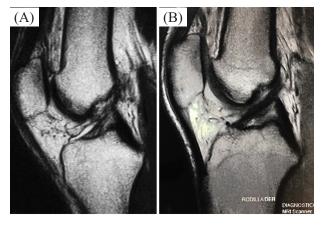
(A) Preoperative Knee MRI sagittal view showing the heterogeneous hyperintense signal suggestive of partial ACL injury (B) Knee, MRI sagittal view at 8 months, follow up where the hypointense and homogeneous continuous signal of ACL is seen, suggestive of ACL healing.
